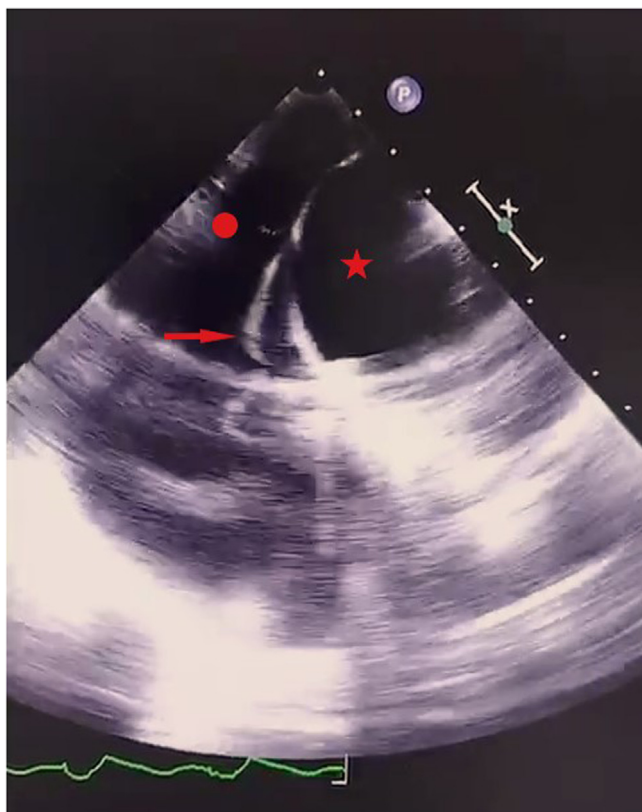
Midesophageal 4-chamber view with transesophageal probe rotated towards the right side showing a worm-like structure (*red arrow*) attached to the right atrium (*red star*). The pleural effusion is indicated by a *red circle*.
